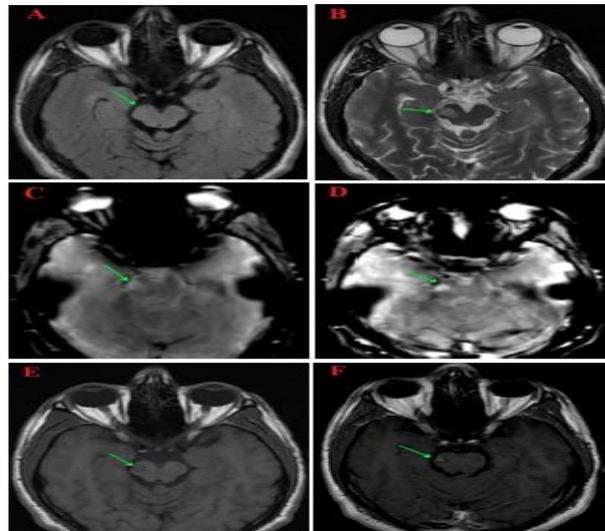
A 22-year-old male patient, presented with, lumbar weakness and visual troubles of two weeks duration. (The initial MRI) A & B): Axial FLAIR and axial T2WI: Show right midbrain hyperintense plaque on T2WI and isointense plaque on FLAIR, C): Axial pre contrast Susceptibility Weighted Images (SWI): Show right midbrain hyperintense plaque, D): Axial post contrast Susceptibility Weighted Images (SWI): shows strong homogenous nodular pattern of enhancement of plaque which demonstrate BBB dysfunction in the plaques that is characterized more obvious by the GD-SWI sequence more than post contrast T1WI, E & F): Axial T1WI (pre and post contrast study): The pre contrast T1WI (E) shows right midbrain hypointense plaques, the post contrast T1WI (F) shows faint nodular pattern of enhancement of plaque (arrow).
